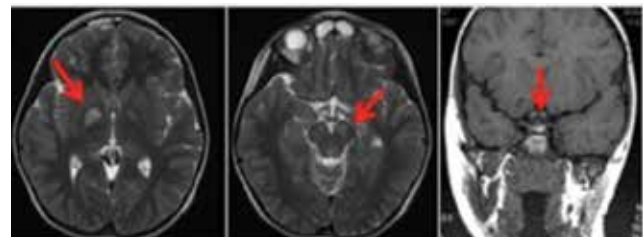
Cranial magnetic resonance imaging of the patient showing the lesions of neurofibromatosis in the cerebral peduncles and globus pallidus and adenopituitary hypoplasia in the pituitary
